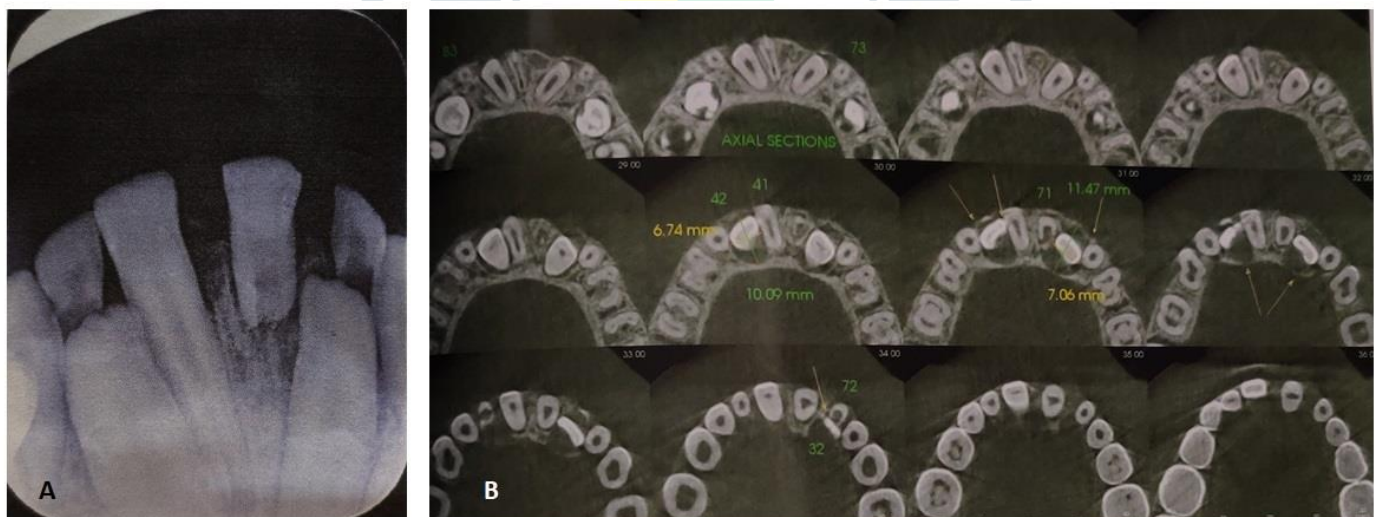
(A) An intra-oral peri apical radiograph revealing root resorption of the apical third of the left permanent mandibular central incisor.
